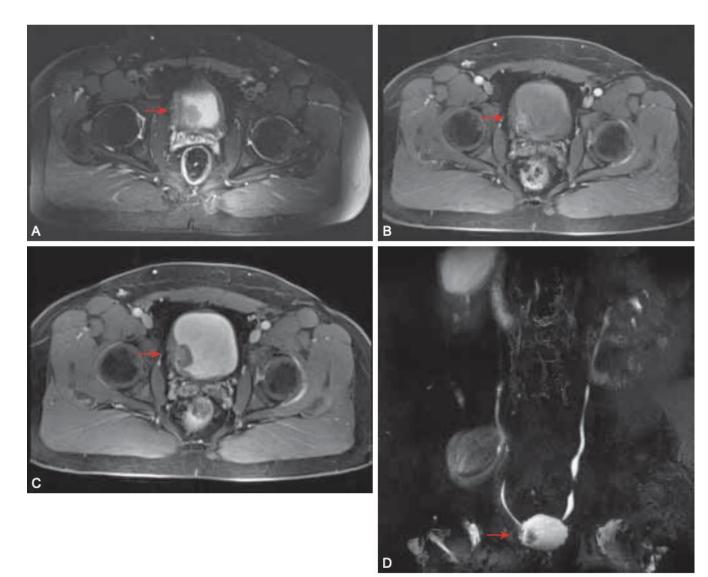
MRI (A 51-year-old man with a history of gross hematuria underwent a 1.5-tesla magnetic resonance urogram. A, T2 fat-saturated sequence with high T2 signal in bladder (urine). Right bladder wall low signal intensity filling defect (*red arrow*).
